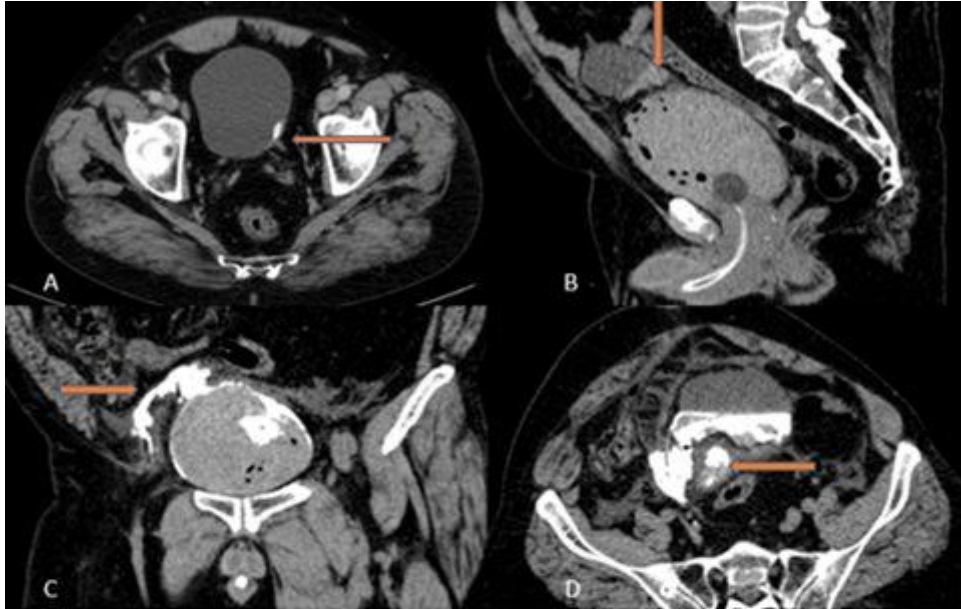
Abdominal-pelvic CT with portal IVC, axial section. TAC of control of patient's vegiga cancer. In the left lateral wall of the vegiga, an image of calcium density adjacent to the ureteral meatus is visualized. Although it could be related to lithiasis, it seems to be associated with soft tissue injury (cystoscopy is recommended). FIGURE B: Pelvic CT without IVC, sagittal section. Distended bladder with content of high attenuation in its interior, in relation to blood content. An extravesimal leak of this content is observed. FIGURE C and D: Pelvic CT without IVC and after the administration of contrast through bladder catheter, coronal and axial sections. At the bladder dome, extravasation of the contrast is observed, which extends through the right prevesical space and into the intraperitoneal space. Contrast slightly displaces bowel loops.
